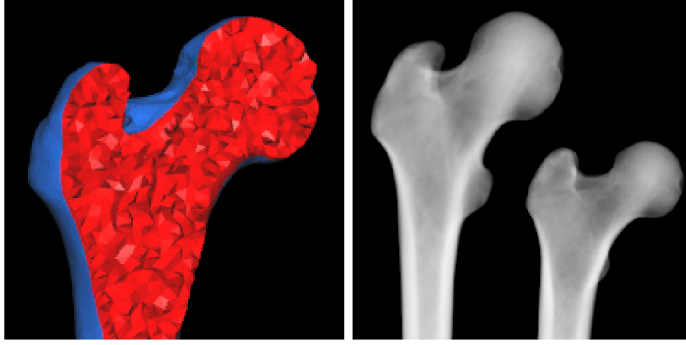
A cross-section of a proximal part of a femoral bone tetrahedral model (left) and two digitally reconstructed radiographs rendered from the statistical shape and intensity model (right).
